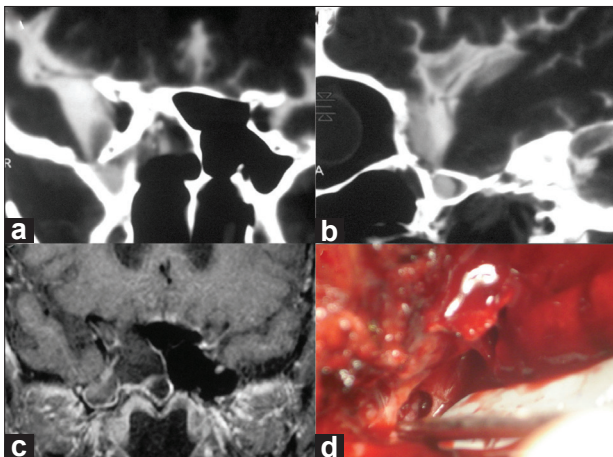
(a and b) Sagittal and coronal CT cisternography; (c) coronal MR image; (d) operative field during dissection of the skull base defect
